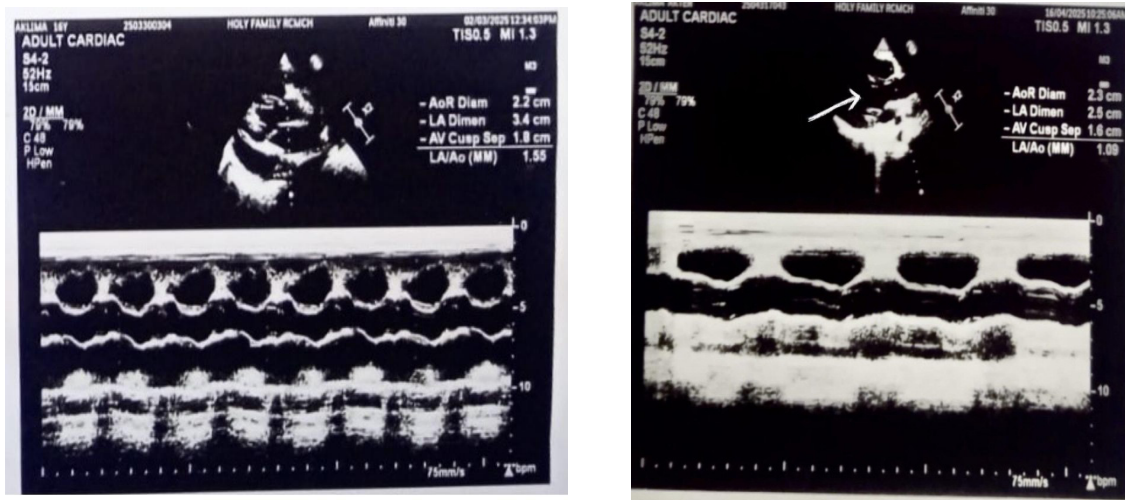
and 1b showing Pericardial Effusion on Echocardiogram, 2D view.
